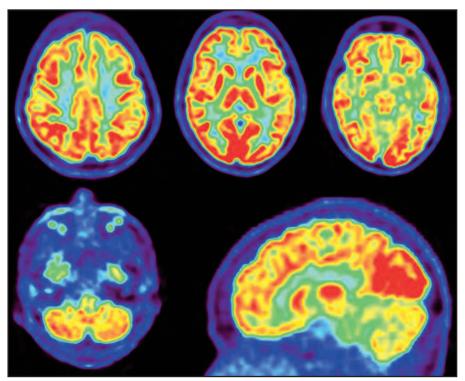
Selected transaxial and sagittal F-18 FDG PET images showed a normal FDG metabolism distribution in the brain. Red regions indicate the highest FDG uptake, primarily in the subcortical putamen, caudate nucleus, and thalamus, with high uptake also in the cortical grey matter (frontal, parietal, and occipital areas) compared to the temporal cortex, especially the medial temporal region and hippocampus. Green regions represent intermediate uptake, while blue regions show the lowest FDG uptake
